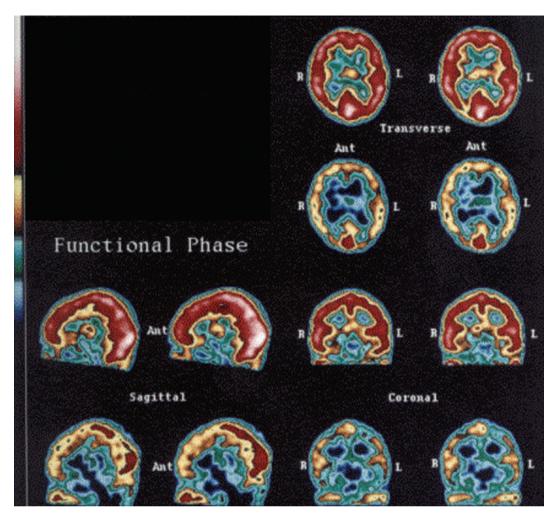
Normal SPECT brain scan – smooth, uniform, distinct outlines, no rough edges or holes in cerebral hemispheres or abnormal temporal lobes. Abnormal SPECT brain scan – rough edges, holes in cerebrum, temporal lobes obliterated or poorly outlined.
